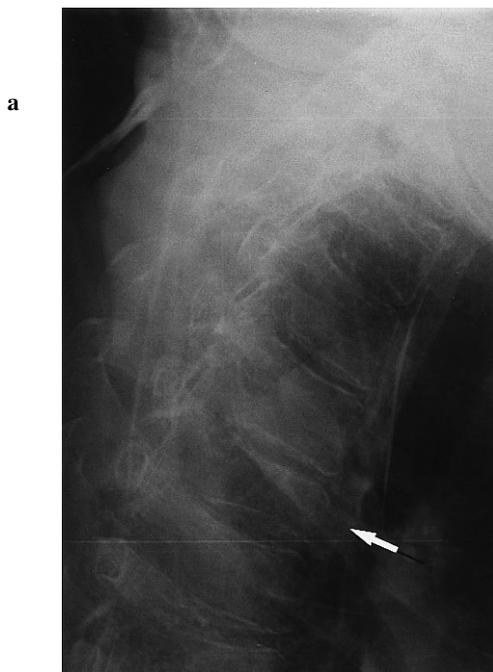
Metastatic tumor of the 5th thoracic vertebra in a 65-year-old man with laryngeal carcinoma. Final diagnosis was made by increasing back pain and progressive destructive change on X-ray of six months later. a) Lateral radiograph shows a compression fracture in the 5th thoracic vertebra (*arrow*). b) Coronal PET image demonstrates a high accumulation of FDG (SUV = 4.99) in the tumor (*arrow*).
